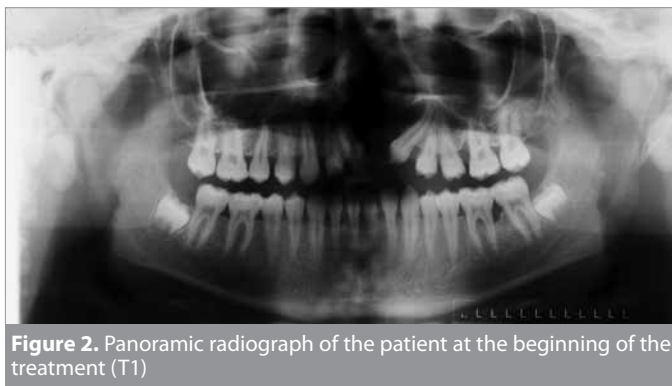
Panoramic radiograph of the patient at the beginning of the treatment (T1)
